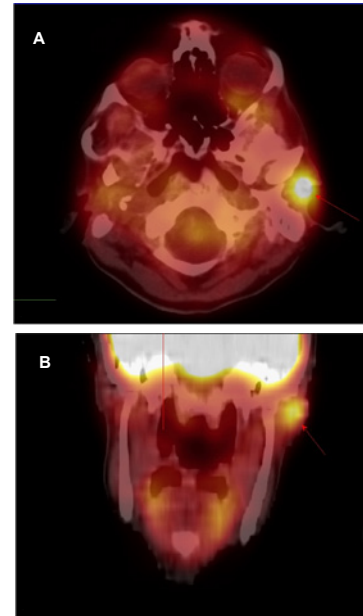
(A-B) Fused PET/CT coronal and axial images demonstrate increased FDG uptake in the hyperdense lesion in the lateral aspect of the EAC.
